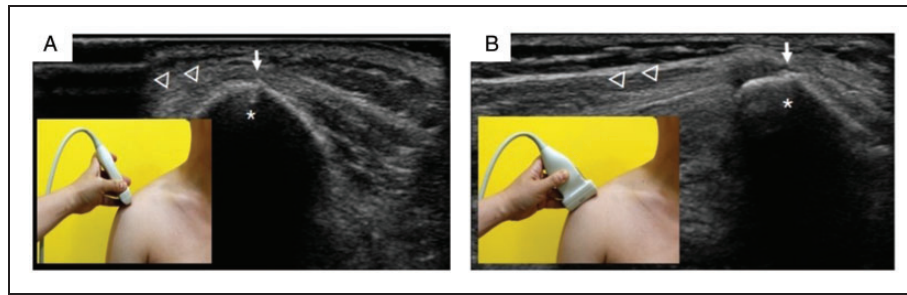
Acromial stress occult fracture site. A, Longitudinal ultrasonography. B, Transverse ultrasonography. The fracture was diagnosed based on a radiographic finding of cortical discontinuity and periosteal thickening.
